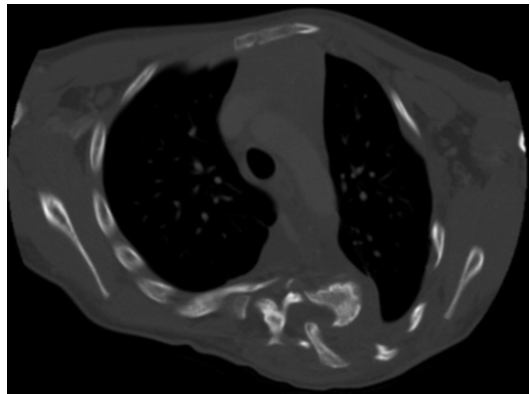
Dislocation of rib head in the spinal canal in a severe dystrophic thoracic curve. Careful evaluation of the preoperative imaging including CT scan is essential to identify this pathology. Decompression prior to correction is essential to prevent intraoperative neurological complications
